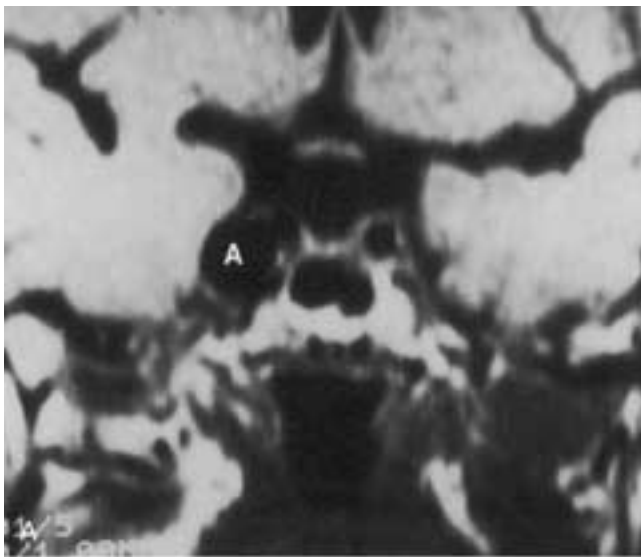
Aneurysm. A, T1-weighted image without contrast. The aneurysm (A) causes the wall of the cavernous sinus to bulge laterally and is seen as a flow void in the region of the cavernous sinus. B, Axial scan again shows the aneurysm (A). It impinges posteriorly on the anterior part of Meckel's cave. The fat in the superior orbital fissure is maintained. C, Anteroposterior view of the aneurysm during injection arteriography. The aneurysm (A) can be seen in the cavernous segment of the carotid artery.
